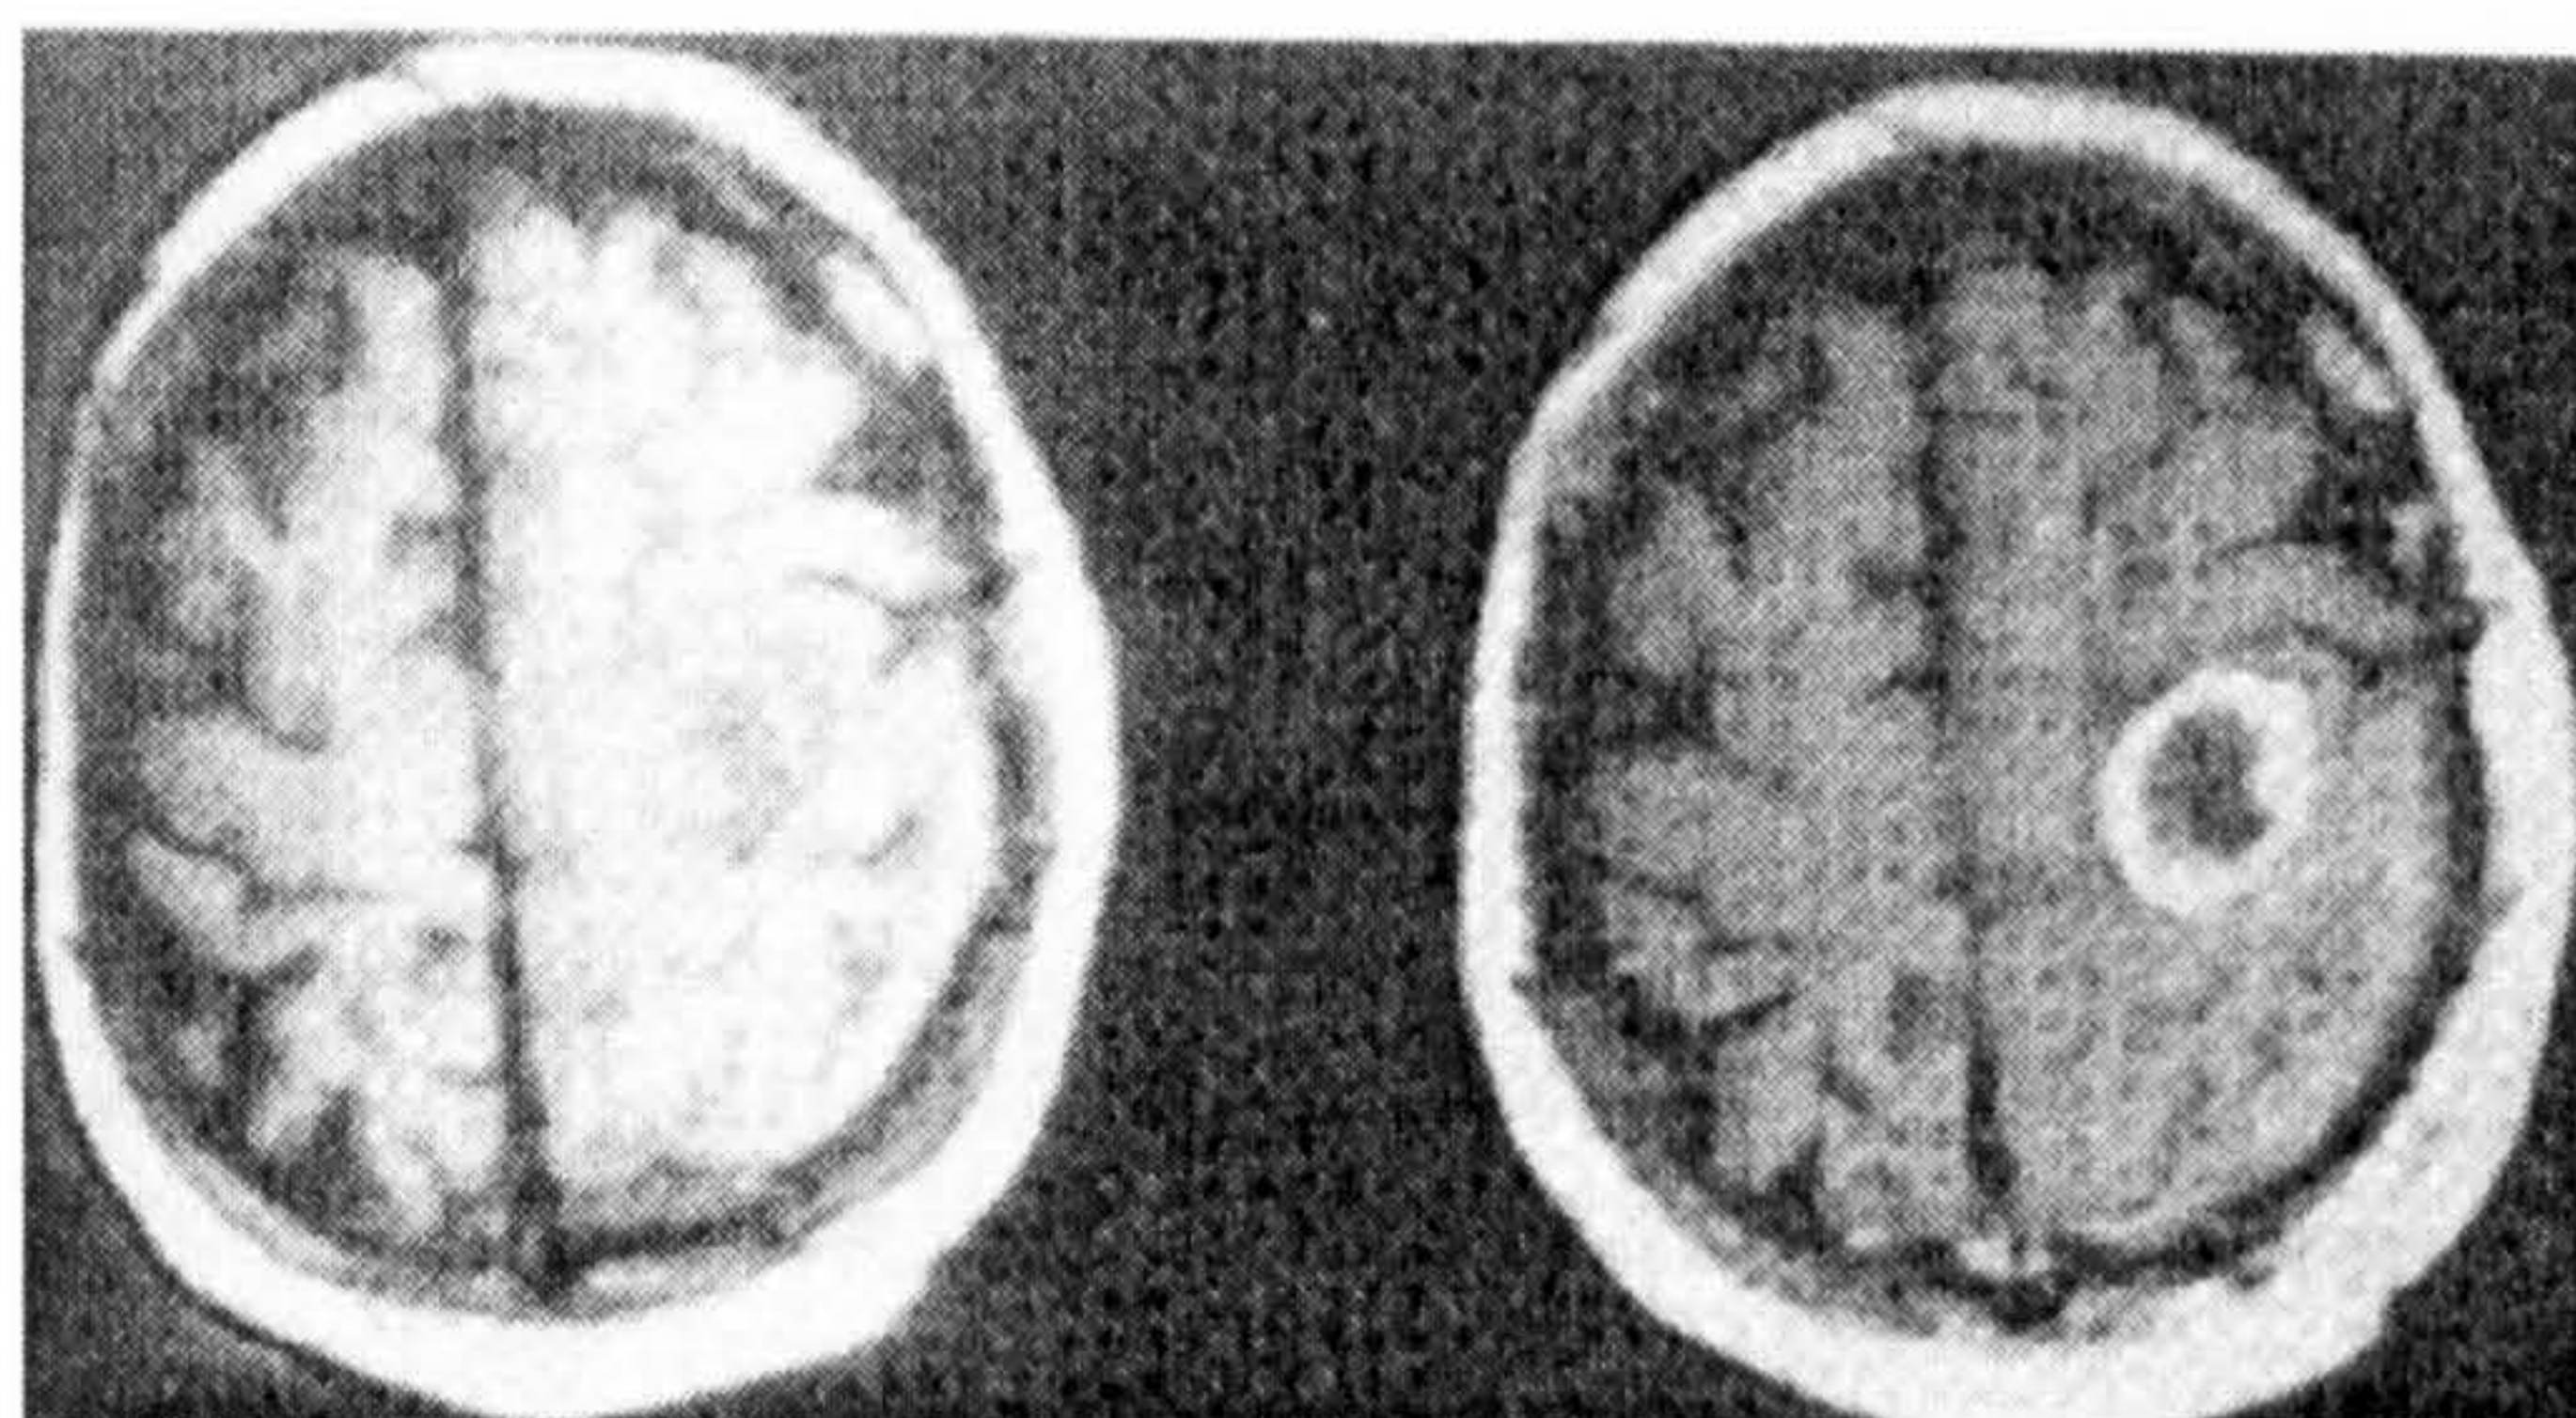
Transverse MRI images through a brain of a patient before (left) and 3 minutes after (right) intravenous injection of $[\text{Gd}(\text{DTPA})(\text{H}_2\text{O})]^{2-}$ showing a tumour.
